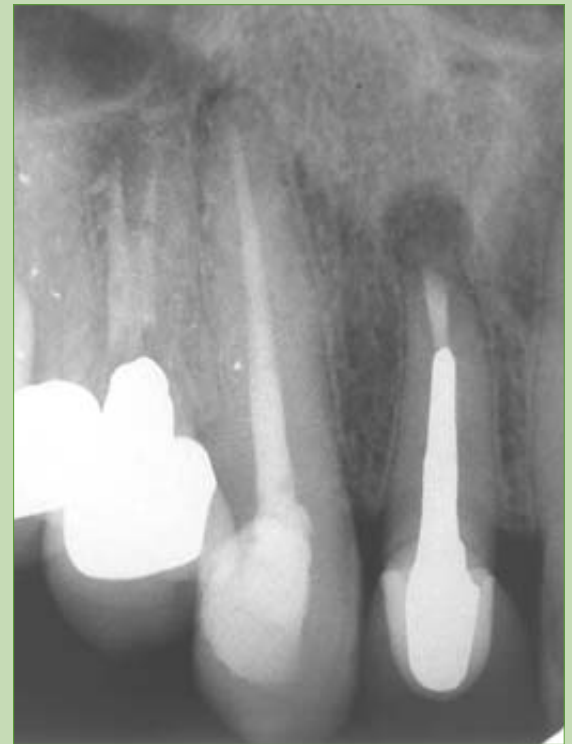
Radiograph of upper right lateral with apicoectomy.
